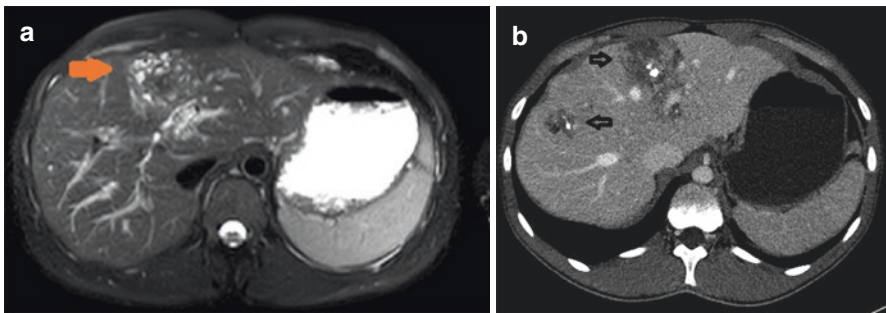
Case 4: Infectious diseases. (a) MRI at first presentation: predominantly cystic-appearing liver lesion. (b) CT scan: clear calcifications within the lesions, raising suspicion for echinococcosis
